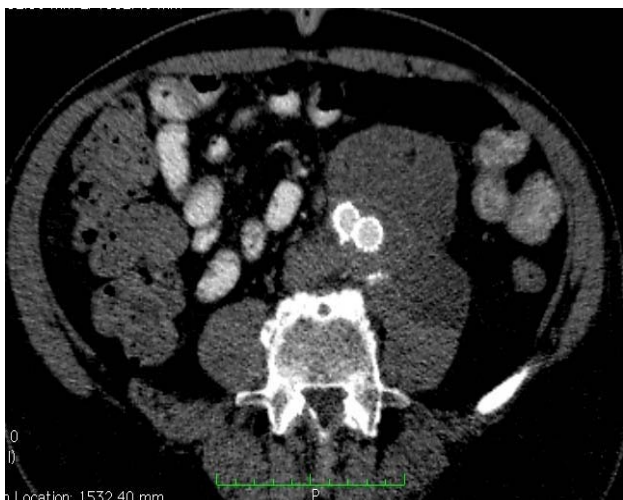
Complete exclusion of the aneurysmal sac, without enlargement of haemathoma and no contrast leakage on post deployment computed tomography scan angiography.
